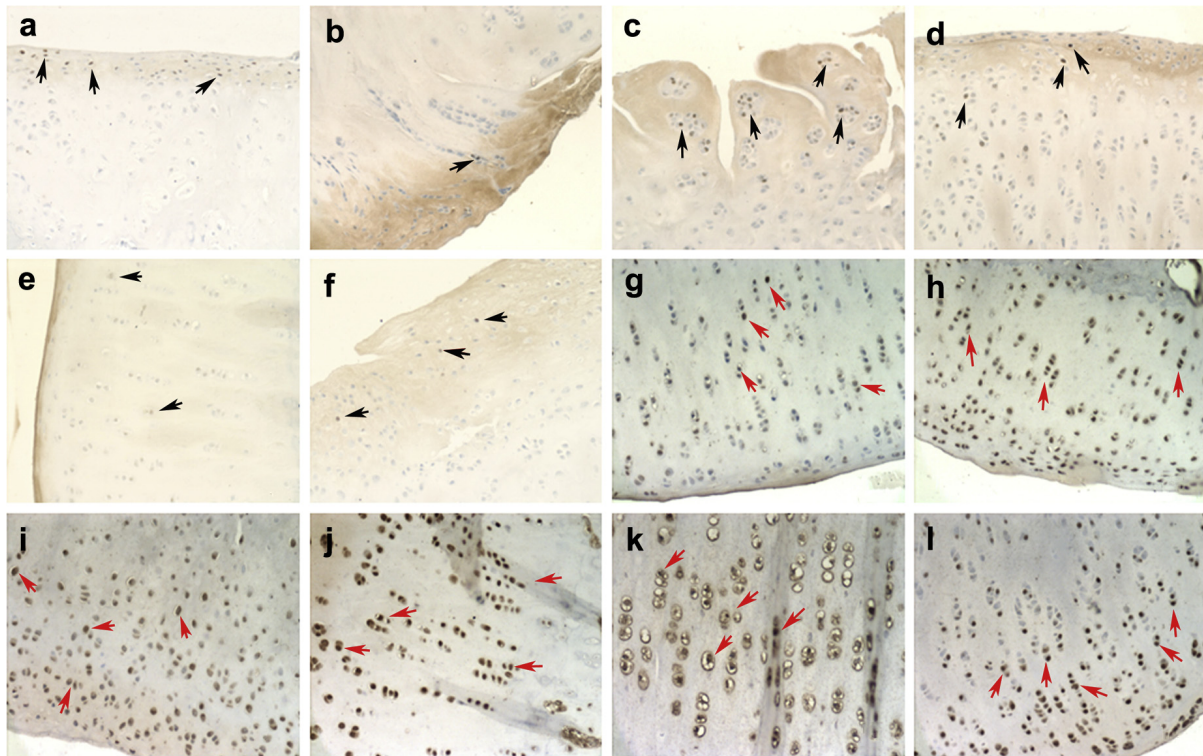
PCNA expression in the each group, $\times 200$ magnification. *Blank arrows* indicate positive cells. (a) FLIPUS intervention at 2 wk; (b) Sham intervention at 2 wk; (c) FLIPUS intervention at 4 wk; (d) Sham intervention at 4 wk; (e) FLIPUS intervention at 8 wk; (f) Sham intervention at 8 wk. Apoptosis in the each group, $\times 200$ magnification. *Red arrows* indicate apoptotic cells. (g) FLIPUS intervention at 2 wk; (h) Sham intervention at 2 wk; (i) FLIPUS intervention at 4 wk; (j) Sham intervention at 4 wk; (k) FLIPUS intervention at 8 wk; (l) Sham intervention at 8 wk ($n = 10$ knees each). FLIPUS = focused low-intensity pulsed ultrasound.
